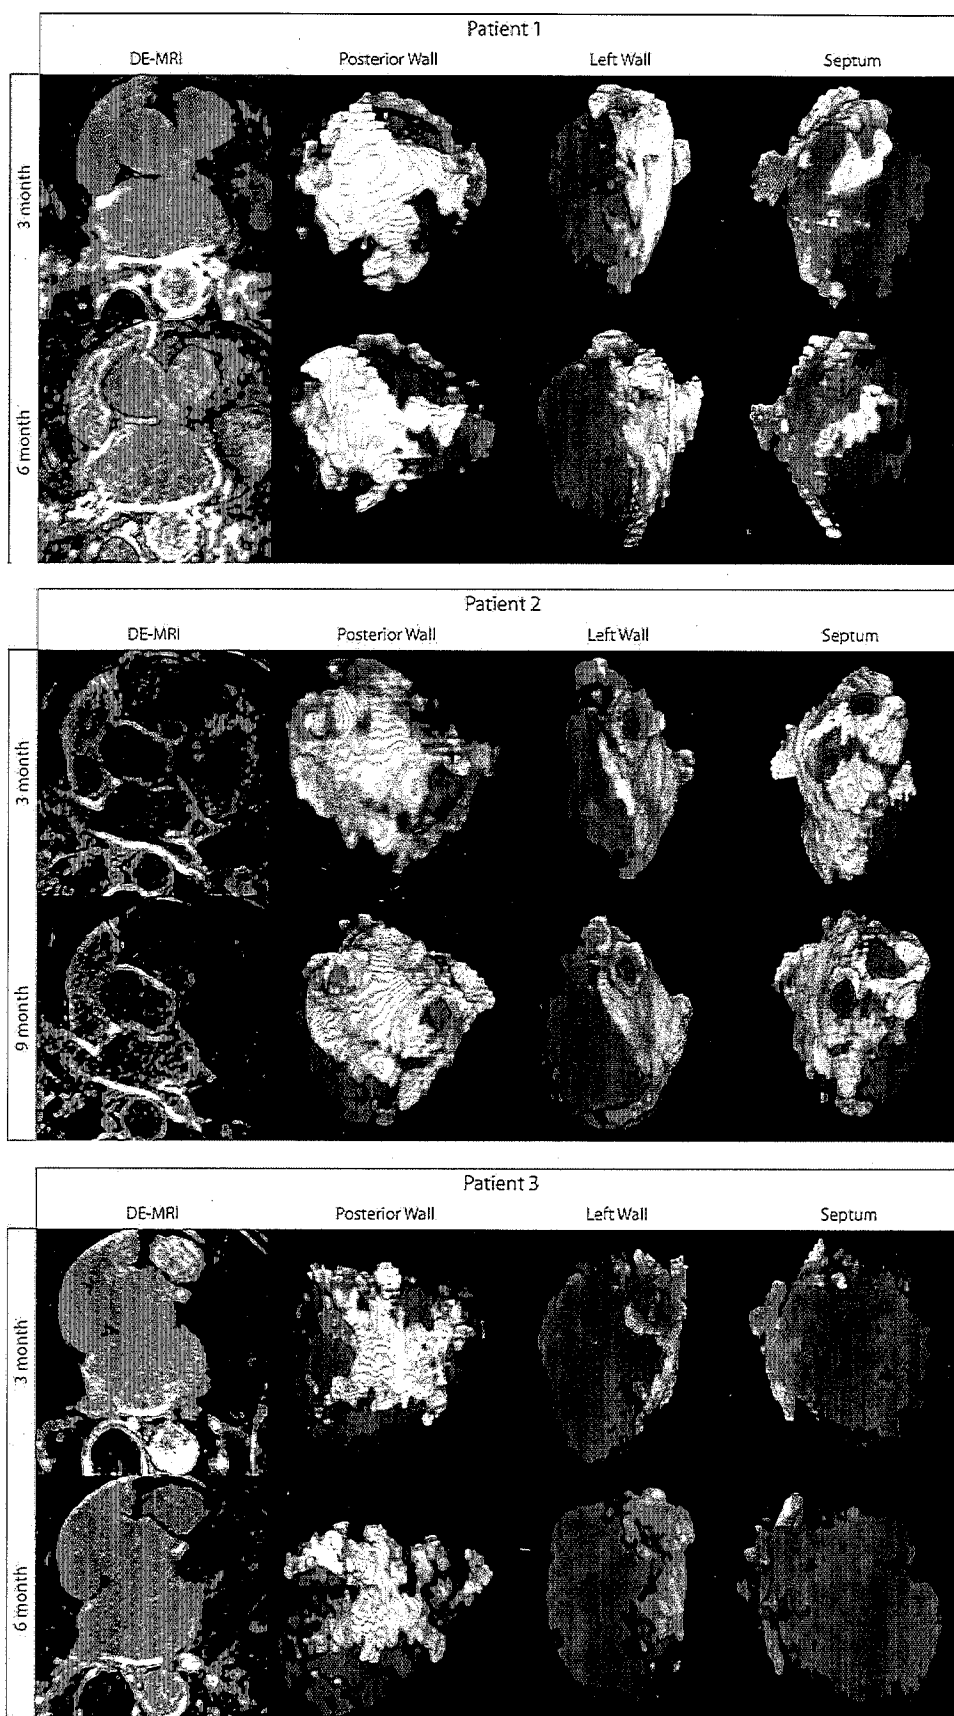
MRI scans acquired at 3 months (*top*) and 6 months (*bottom*) in three patients. Enhancement intensity and location are similar in the two-dimensional MRI slices (*left*) at both time points. Three-dimensional reconstructions in three views (posterior, left lateral, and right lateral) show scarring that is consistent between the 3- (*top*) and 6-month (*bottom*) scans, indicating minimal changes in enhancement between these two time points.
